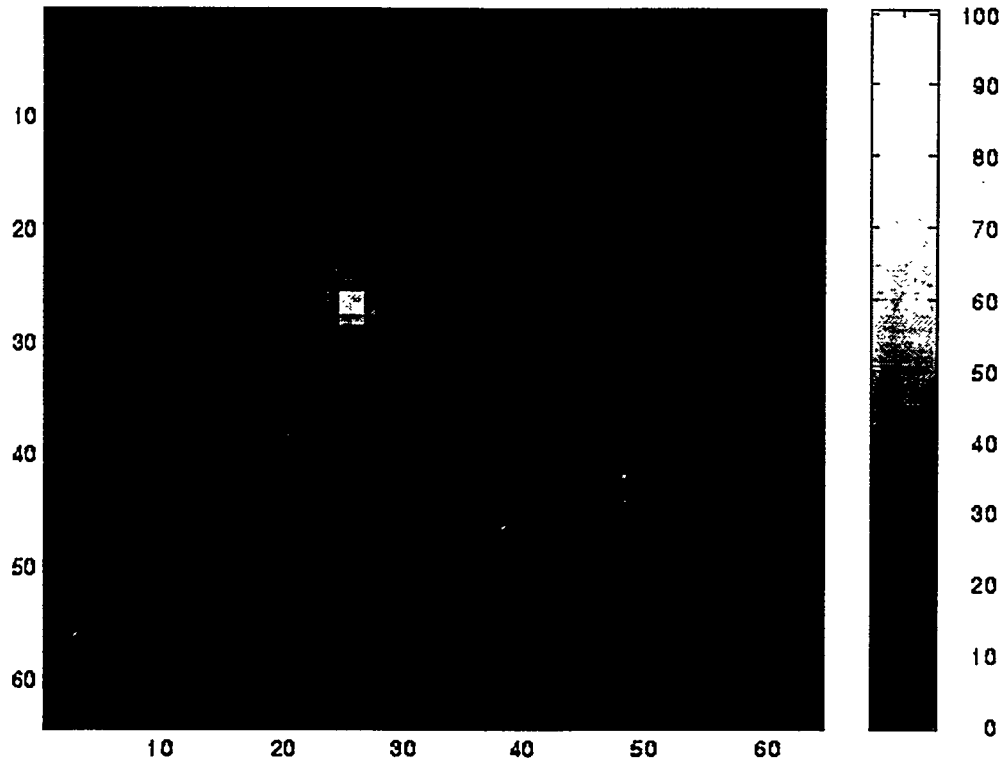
Relative dose distribution for Slice 3 (above) along with the original SPECT image (below).
